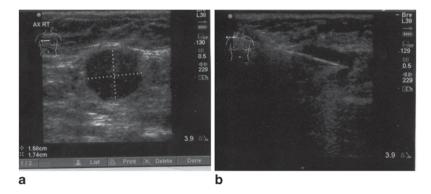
a Ultrasound (US) demonstrating a positive node with rounded shape, hypoechoic, and without cortical structure. b US-guided needle biopsy to confirm nodal positivity
